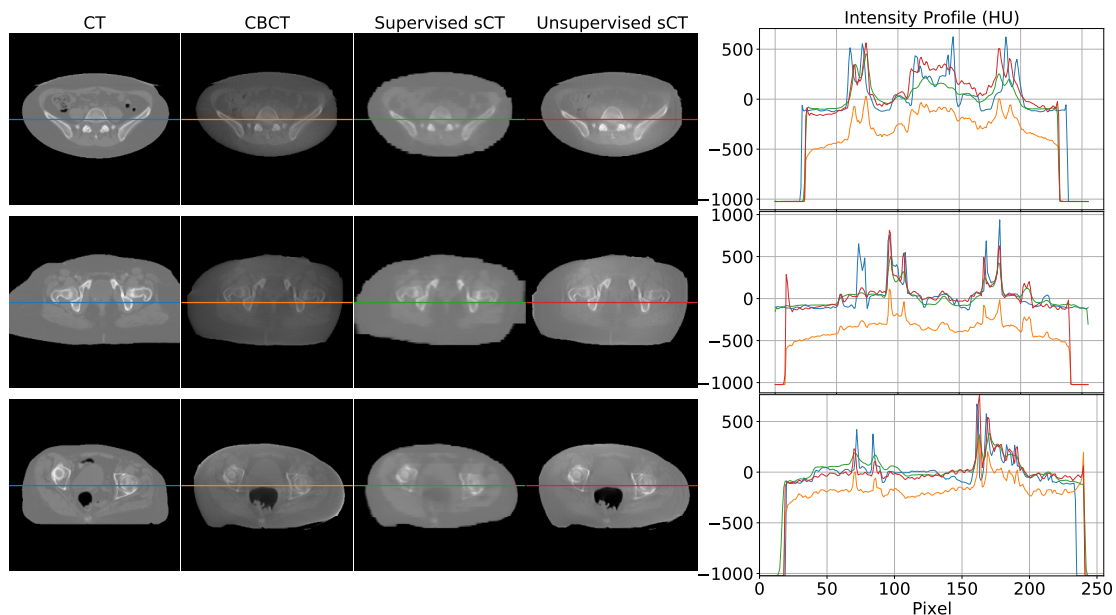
Visual comparison between some axial slices depicted in every modality: CT, CBCT, sCT supervised, and sCT unsupervised. Every row corresponds to a different example taken from a different subject. The rightmost part of the figure compares the intensity profiles of the central line of the images, highlighted by the central line in the four representations. Images are displayed with Window = 2000, Level = 0.
